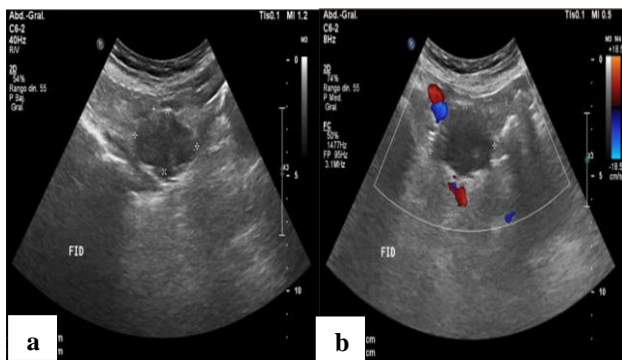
(a) and (b) Abdominal ultrasound showing right iliac fossa lesion suggestive of plastron due to acute appendicitis, doppler vision of the identified lesion.
